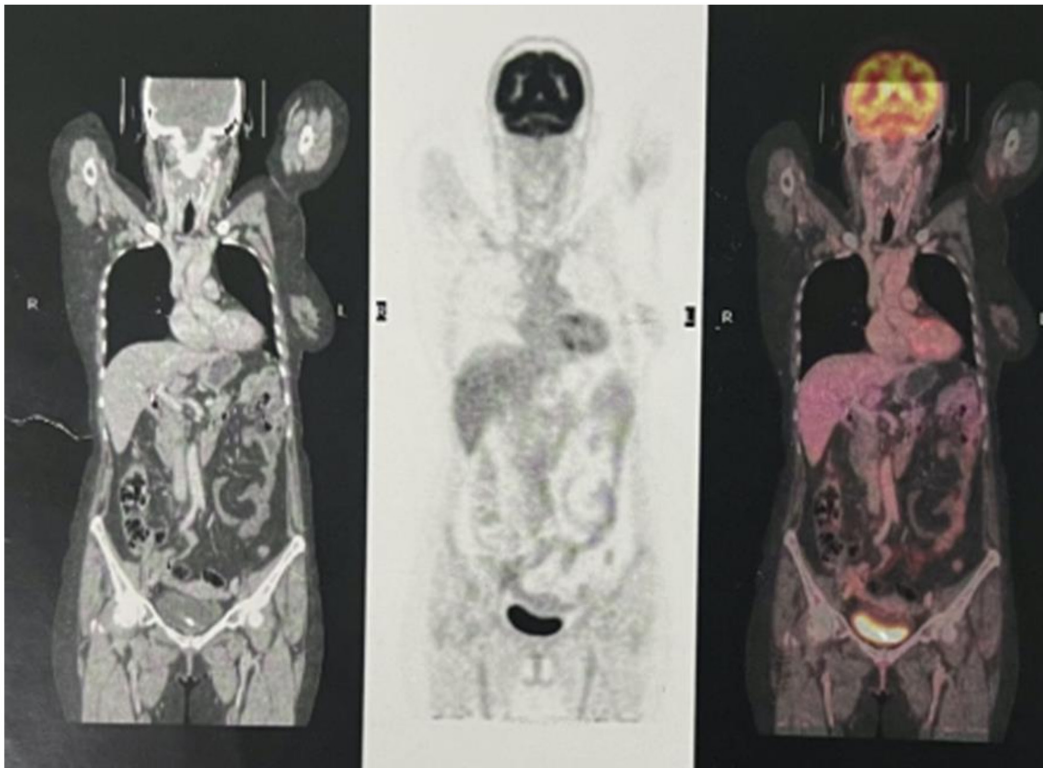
Positron emission tomography-computed tomography scan following diagnosis of leiomyosarcoma, which indicated no evidence of metastasis.
